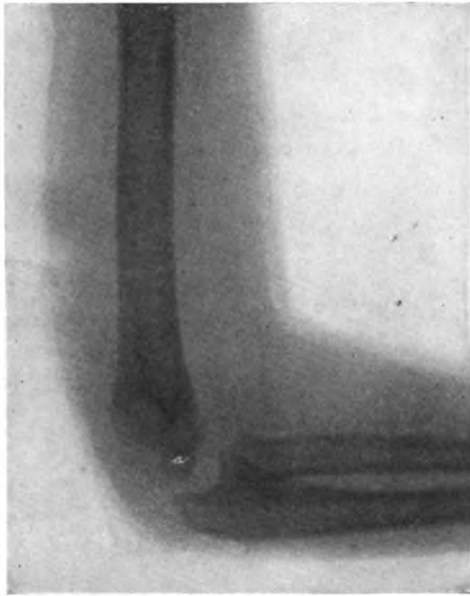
Lateral radiograph of normal elbow at age of eight years: *a*, Radial head of humerus ossified but not united. This might be mistaken for an epiphyseal diastasis (Dr. H. E. Wise, St. Bartholomew's Clinic).
